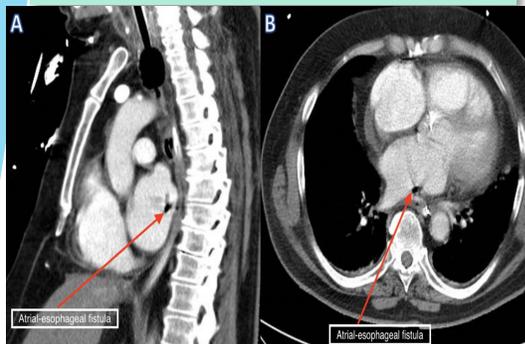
Chest computed tomography scan with contrast showing air contrast (red arrows) within the cavity of the left atrium in the sagittal (A) and axial (B) views.
